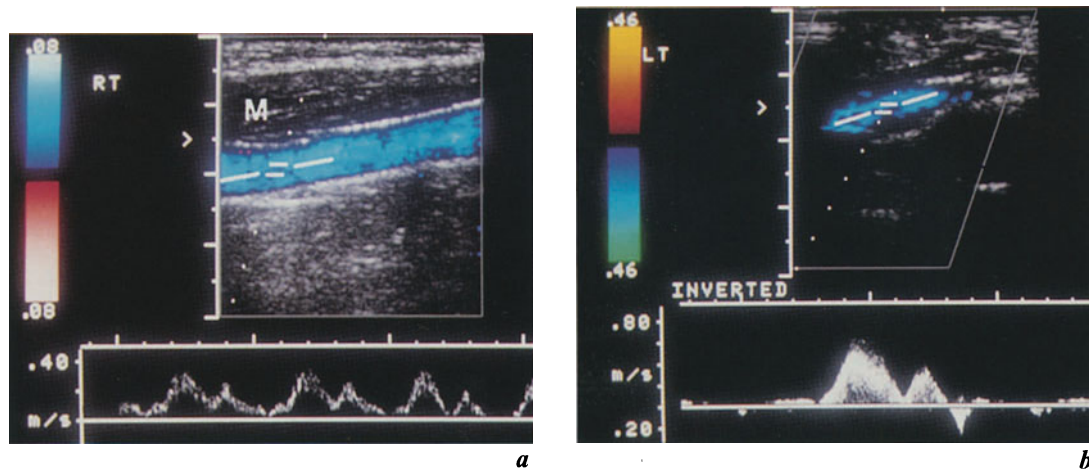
Normal IJV with Doppler spectrum (M = sternocleidomastoid muscle): alternating accelerations and decelerations of blood flow velocity are related to cardiac dynamics (see text for details)
